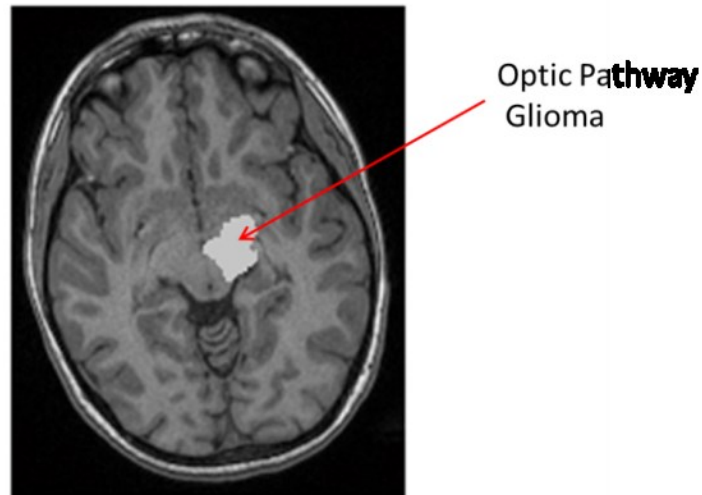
The anatomical MRI template indicating the area of artificial OPG
